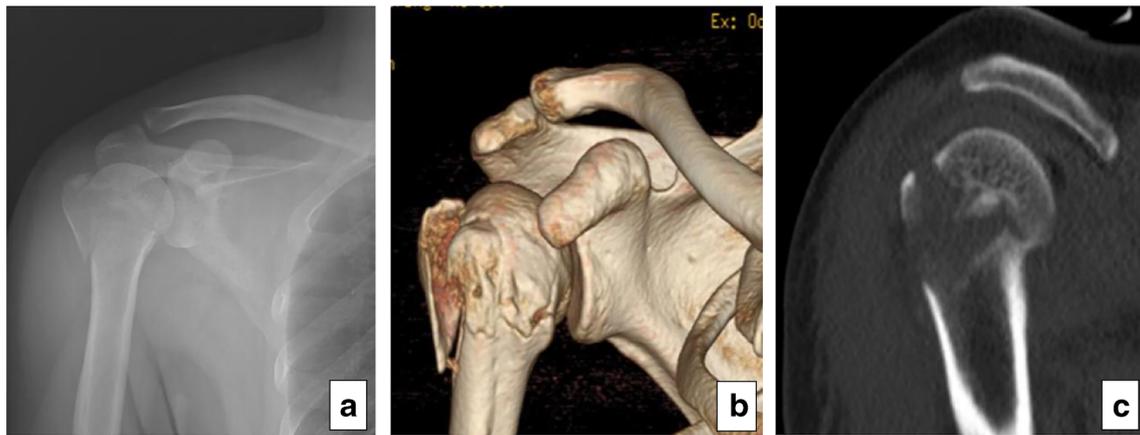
Inferior displacement sign. a Inferior displacement sign on AP view X-ray image, while the humeral neck fracture was not obvious. b 3D-CT reconstruction shows the GT fragment had posterior/inferior
